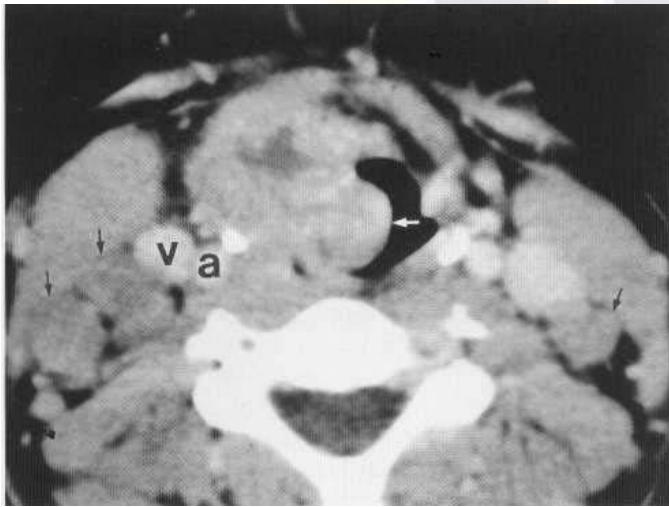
Axial enhanced CT section of a supraglottic laryngeal carcinoma (white arrow) with multiple nodal metastases (black arrows). a = carotid artery; v = internal jugular vein.
